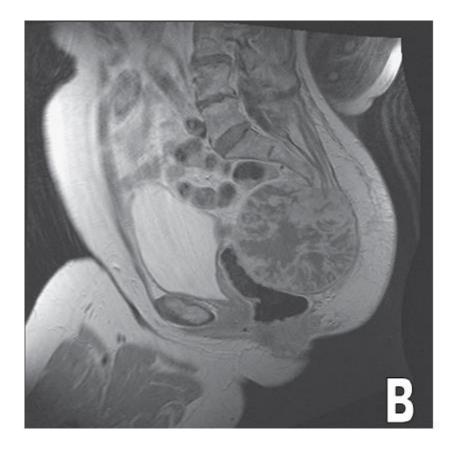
A and B: Sacrococcygeal chordoma. Sagittal T2-weighted (A) and postcontrast T1-weighted (B) sequences show a large, relatively heterogeneous tumor of the os coccygis.
